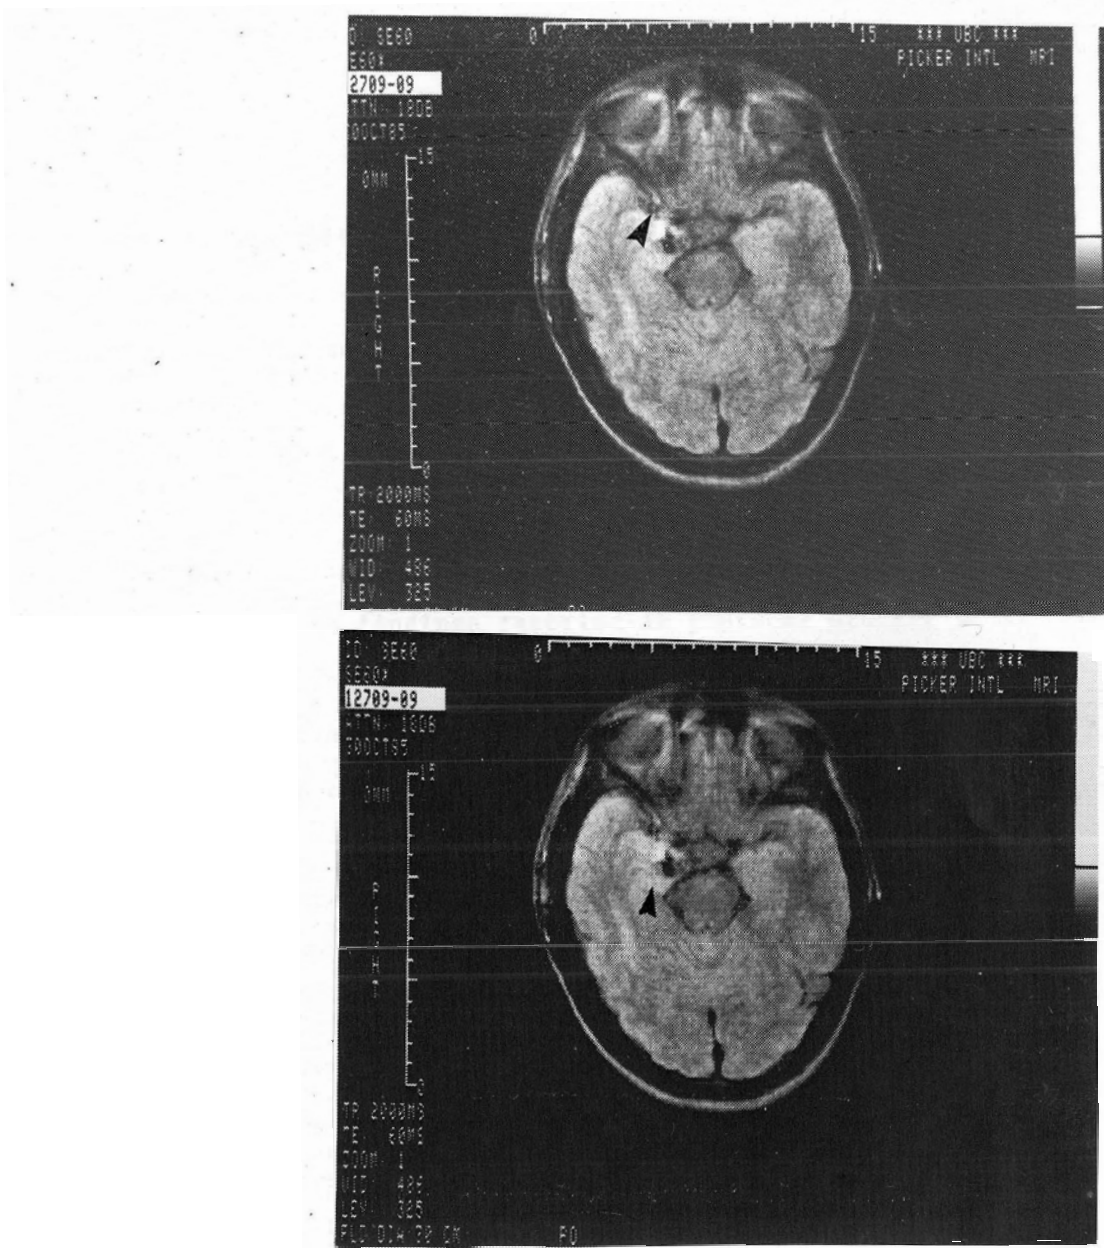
MRI with dipoles indicated for subject RZ.
